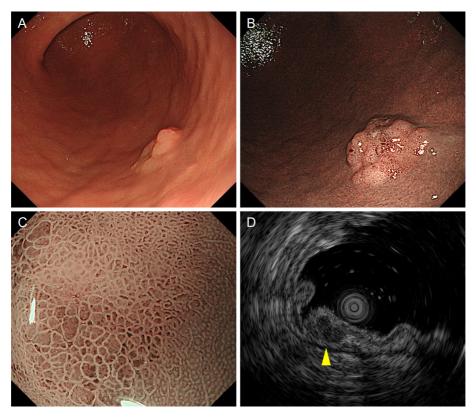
Endoscopic images of the case with gastric LMS. White light imaging and NBI with and without magnification showed a discolored, elevated subepithelial tumor with an uneven surface on the greater curvature of the gastric lower body (A-C). EUS with a 20 MHz miniprobe showed a homogeneous hypoechoic mass (yellow arrowhead) in the second and third sonographic layers. However, the third sonographic layer was not broken (D). LMS: leiomyosarcoma, NBI: narrow band imaging, EUS: endoscopic ultrasonography
